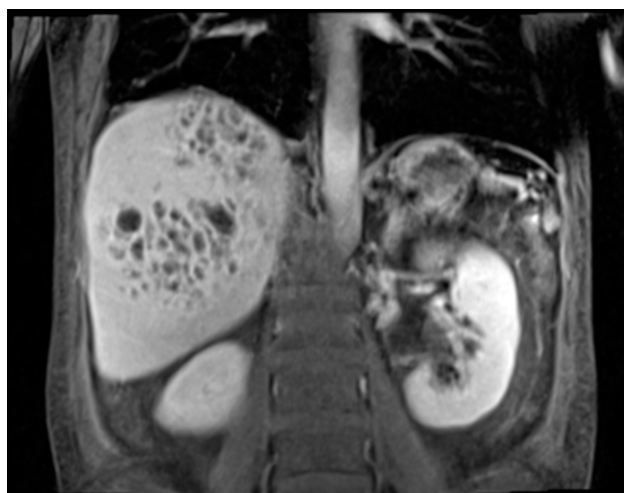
Coronal section of magnetic resonance imaging
